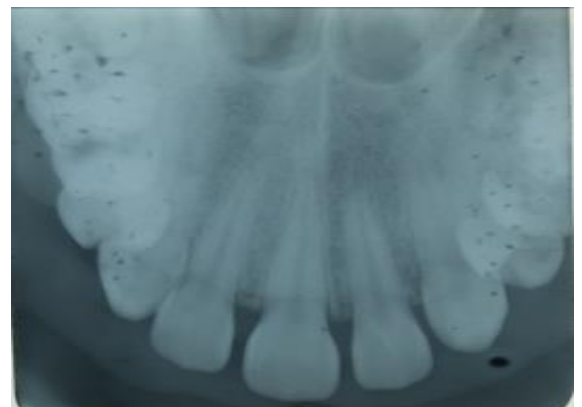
Pretreatment standard occlusal radiograph of the maxillary arch
